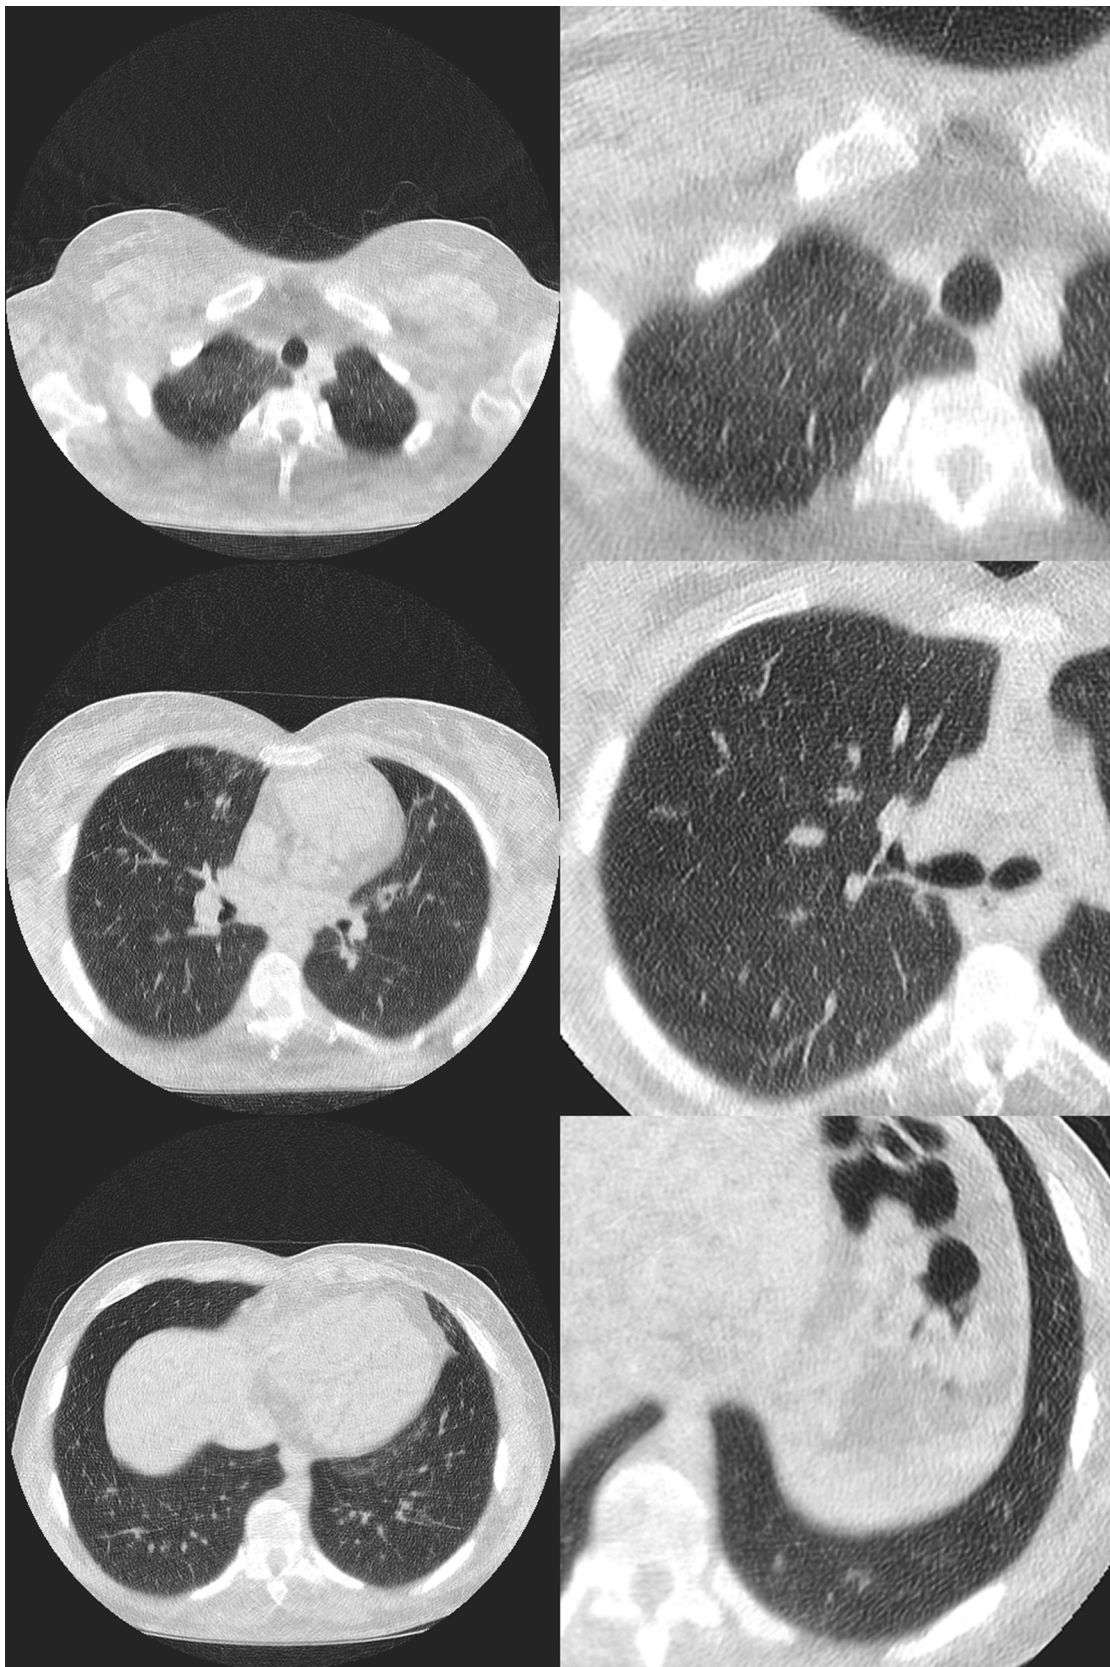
Exemplary slices of a lung CT in a 17-year-old patient, considered unacceptable to limited quality, conducted on MDCT 2 with 100 kVp, 10 mA, 2.8 mAs, 0.9 mSv. Left row shows full FOV, right magnified sections (slices not corresponding). Note the partially substantial loss of details due to photon starvation, especially apical (first row).
